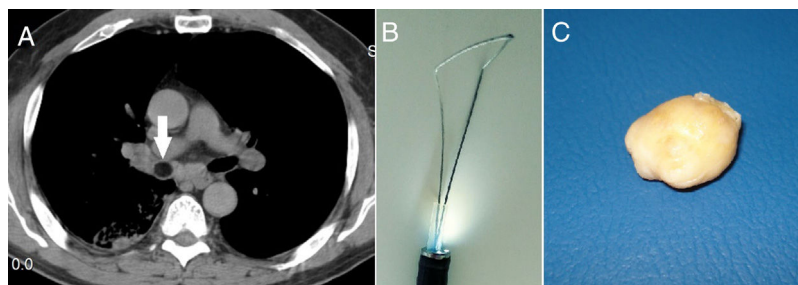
(A) Computed tomography showing the endobronchial lipoma blocking the right main bronchus (white arrow). (B) Our snare mounted in the flexible bronchoscope. (C) 15-mm lobulated soft tissue mass of almost excised lipoma.
